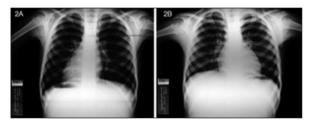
A: Anteroposterior chest radiography of twin 1 showing heart and gastric fundus air on the right, B: Anteroposterior chest radiography of twin 2.
